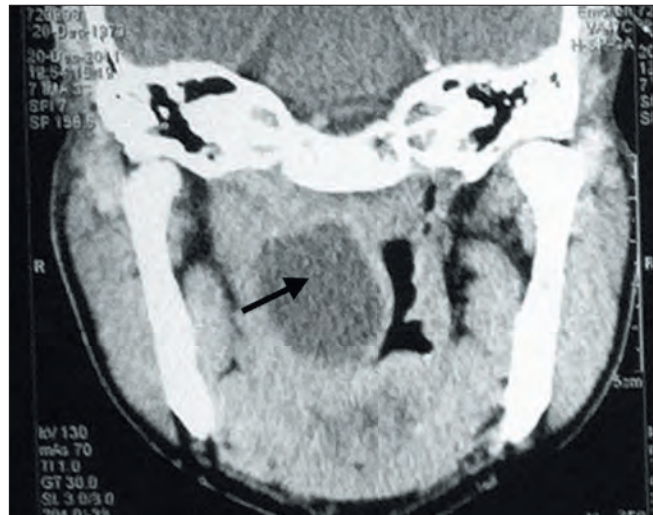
Computed tomography scan of the neck, coronal section (contrast) showing abscess (well-defined hypodense necrotic lesion with minimal peripheral rim enhancement, arrow).
